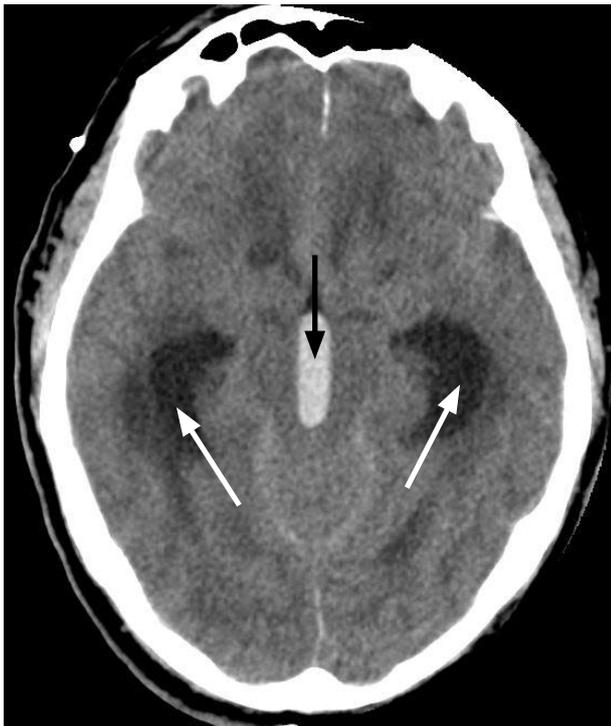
This CT scan shows obstructive hydrocephalus secondary to a third ventricular haemorrhage. The white area in the centre is fresh blood within the third ventricle (black arrow) and the dark areas on either side are dilated temporal horns of the lateral ventricles (white arrows). It is unusual to see the temporal horns this clearly at this level of the brain and temporal horns greater than 2mm are diagnostic of hydrocephalus.
